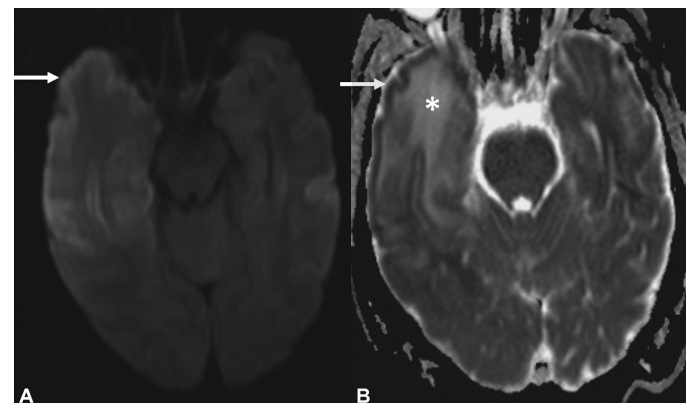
Acute HSV encephalitis. *A:* This b1000 DWI sequence shows unilateral, asymmetric thin cortical restricted diffusion with hyperintense signal (*arrows*). There was extension into the right insula and inferomedial right frontal lobe (not shown). White matter edema can be seen on the ADC image as hyperintense signal in the anterior right temporal lobe (*).
